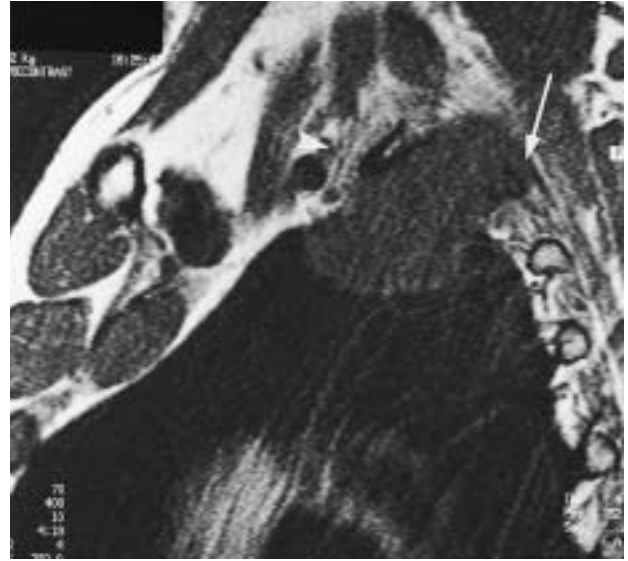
Pancoast tumour. Left-sided sagittal T1-weighted magnetic resonance image accurately displays tumour extension in Pancoast bronchogenic carcinoma with respect to superior sulcus structures. The tumour has invaded the second rib (arrow), reaches the first rib and is already adjacent to the lower fascicles of the brachial plexus, represented by linear structures behind the cross-sectional displayed left subclavian artery (arrowhead).
